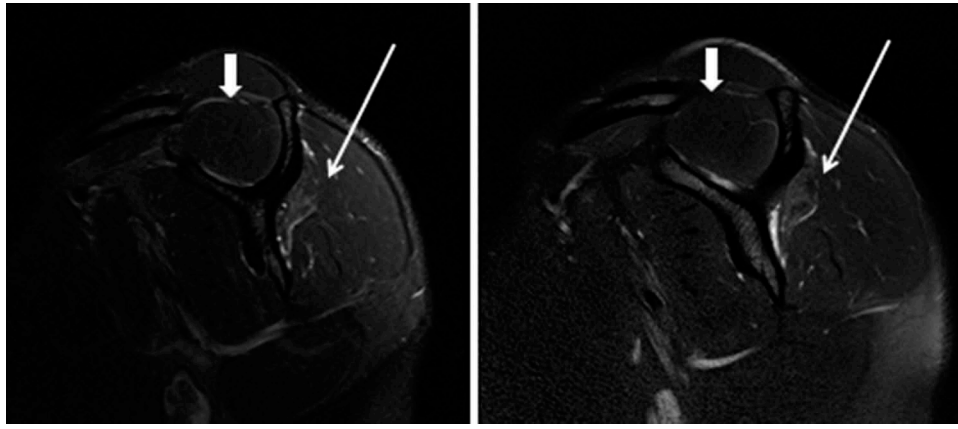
MRI evaluation of muscles trophicity. A 21 years old female player and a 25 years old male player with a grade 2 fatty atrophic infraspinatus muscle (concave profile: long white arrows) are shown on the left and right side, respectively. In both the athletes no hypotrophy of the supraspinatus muscle (convex profile: short white arrows) is present, indicating a nerve entrapment at the spinoglenoid notch.
